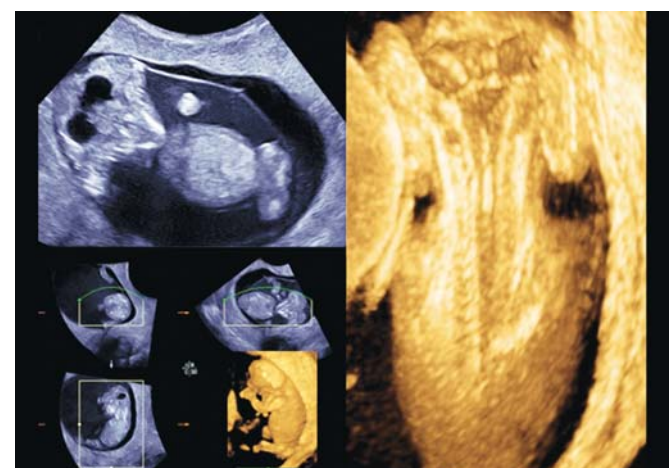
Craniovertebral imaging in an acranial case. Left upper image is 2D ultrasound imaging and left lower image is multiplanar imaging. Right picture shows 3D bony structure of craniovertebral part. Acrania and opening of cervical vertebrae are demonstrated
